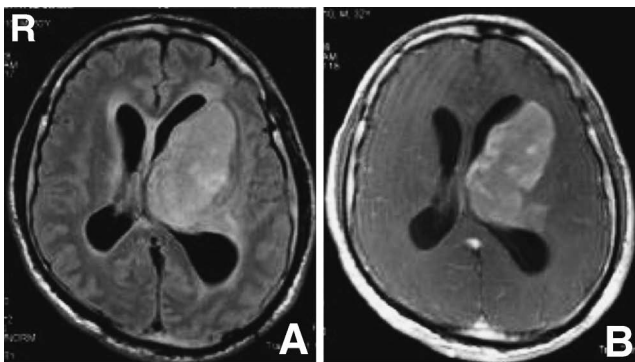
Fluid-attenuated inversion recovery (A) and T₁-weighted magnetic resonance images with gadolinium (B) showing a tumor with mass effect in the left basal ganglia extending to the left parietal lobe, enlargement of the lateral ventricles, and peritumoral edema.
